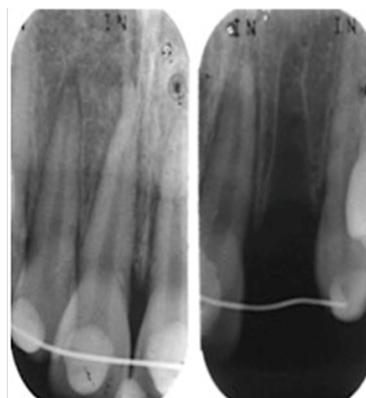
Radiograph post-splinting to verify position of tooth 11 and 21.
